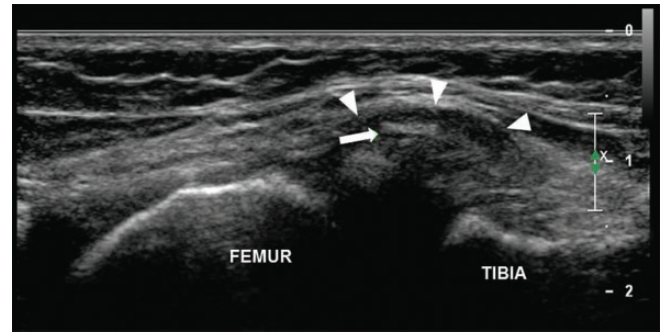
Case 1. Long-axis sonogram over the posteromedial knee, just anterior to the semimembranosus tendon. Arrow demonstrates hyperechoic meniscal suture material. The surrounding hypoechoic tissue (arrowheads) represents inflammatory tissue reaction/adventitial bursa.
